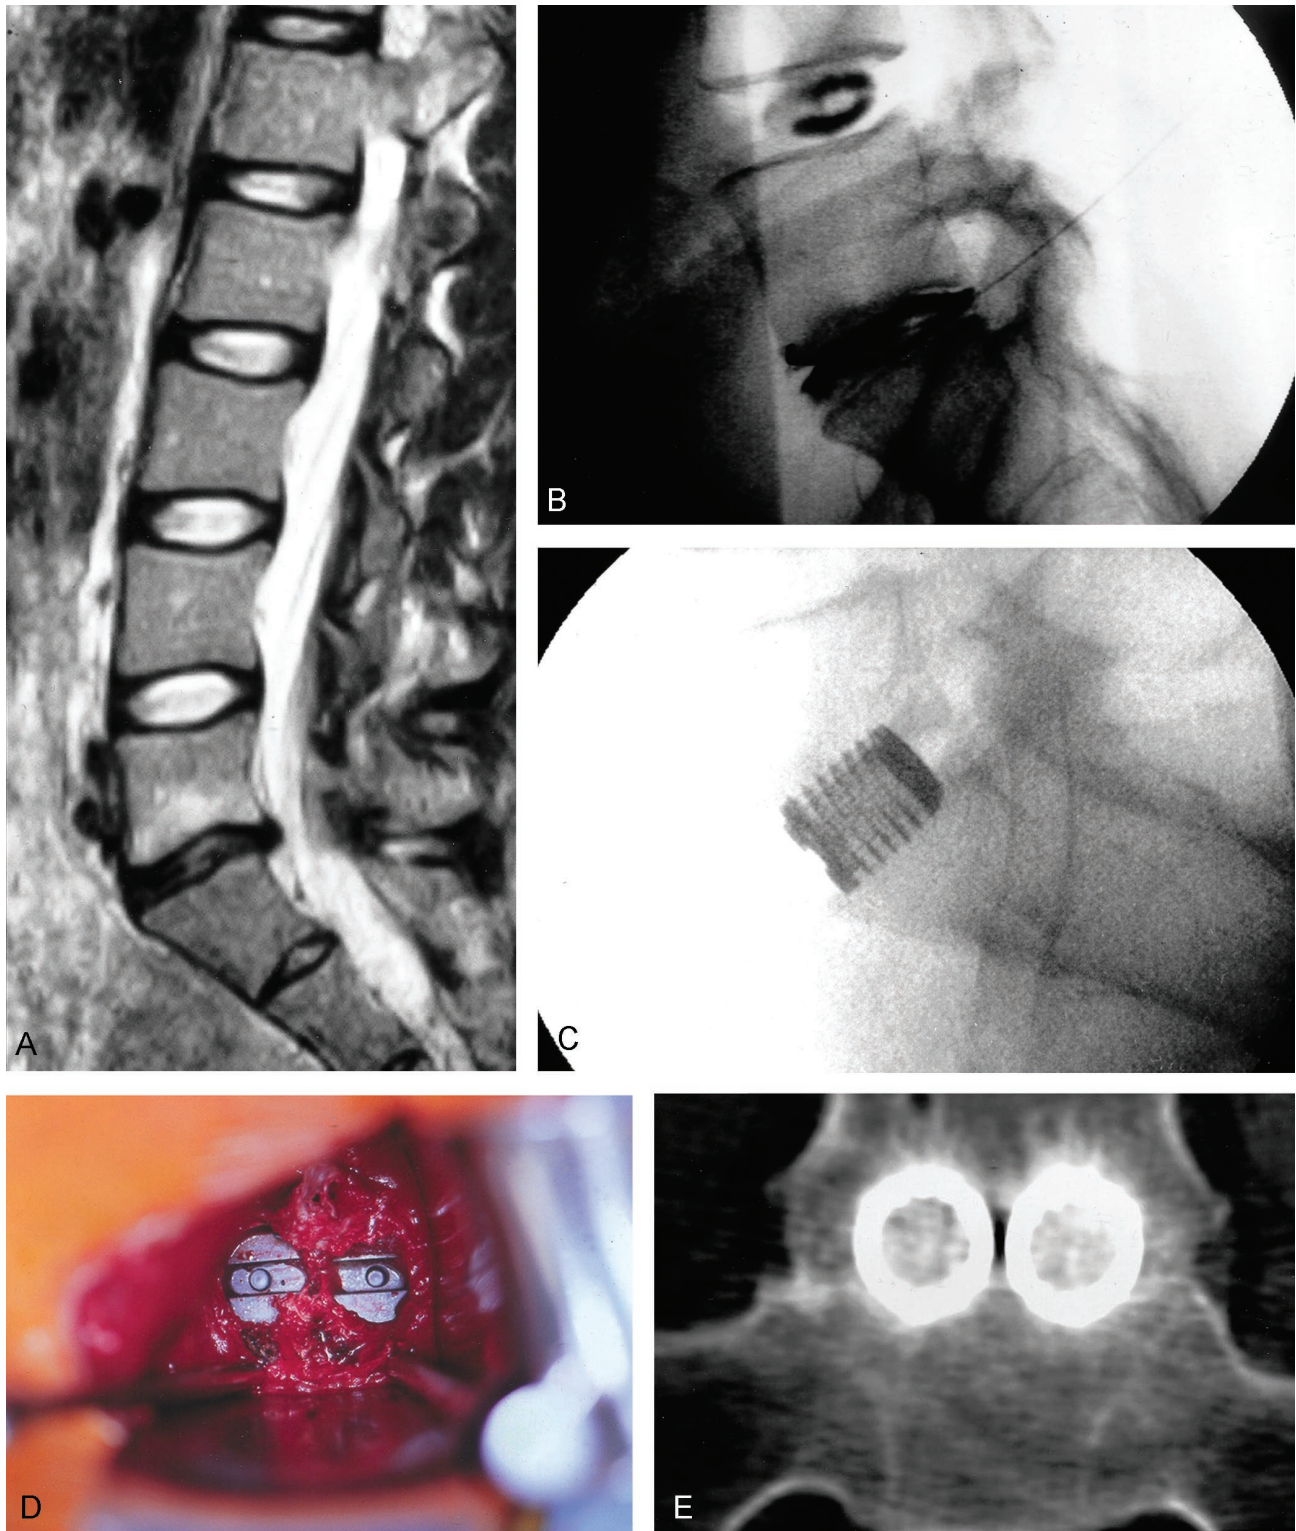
A: Preoperative sagittal T2-weighted MRI with degeneration of the L5–S1 disc and a normal L4–L5 disc. B: Discogram with morphologic abnormality of the L5–S1 disc and a large posterior anular tear. The L4–L5 disc is anatomically normal. Exact concordant 10/10 pain was reproduced at L5–S1. The L4–L5 injection caused no pain. C: Postoperative lateral radiograph with INTER FIX cages in good position. D: Intraoperative picture of the two cages implanted at the L5–S1 interspace. E: Coronal CT scan 1 year postoperative. Bone has grown through and around the cages.
